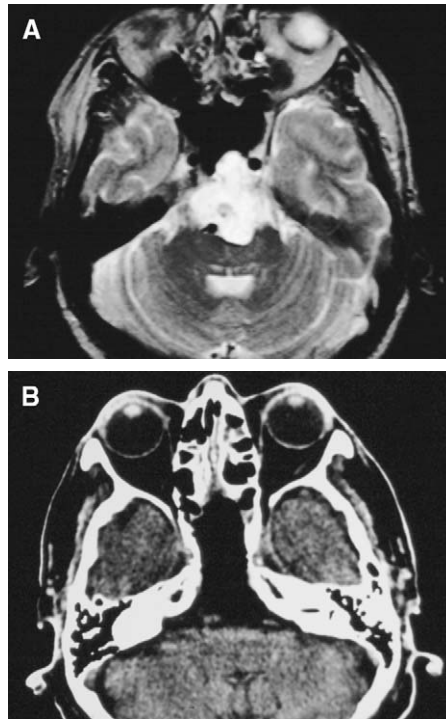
(A) Preoperative axial MRI of a patient who has a clivus chordoma with intradural extension. (B) Postoperative axial CT of the same patient shown in Fig. 7A after endoscopic resection.
